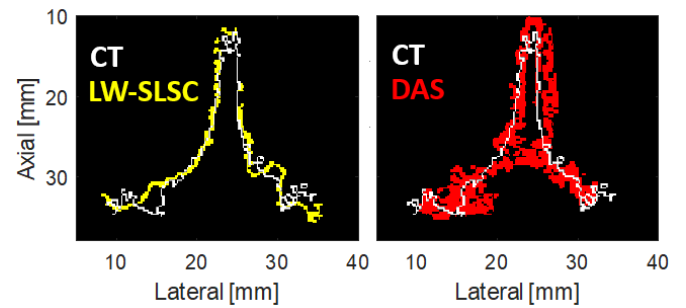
Registered US-CT bone boundaries after applying threshold segmentation to images of the *ex vivo* caprine vertebra. The US images were beamformed using DAS (left) and LW-SLSC (right).
